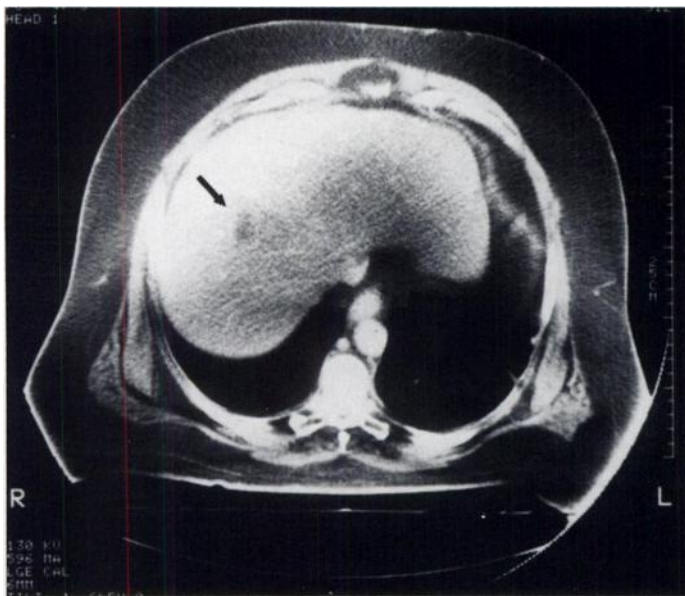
Contrast-enhanced CT performed several days after initial CT shows the hepatic abscess within the right hepatic lobe to be more mature and focal. No other hepatic abnormalities are present.
